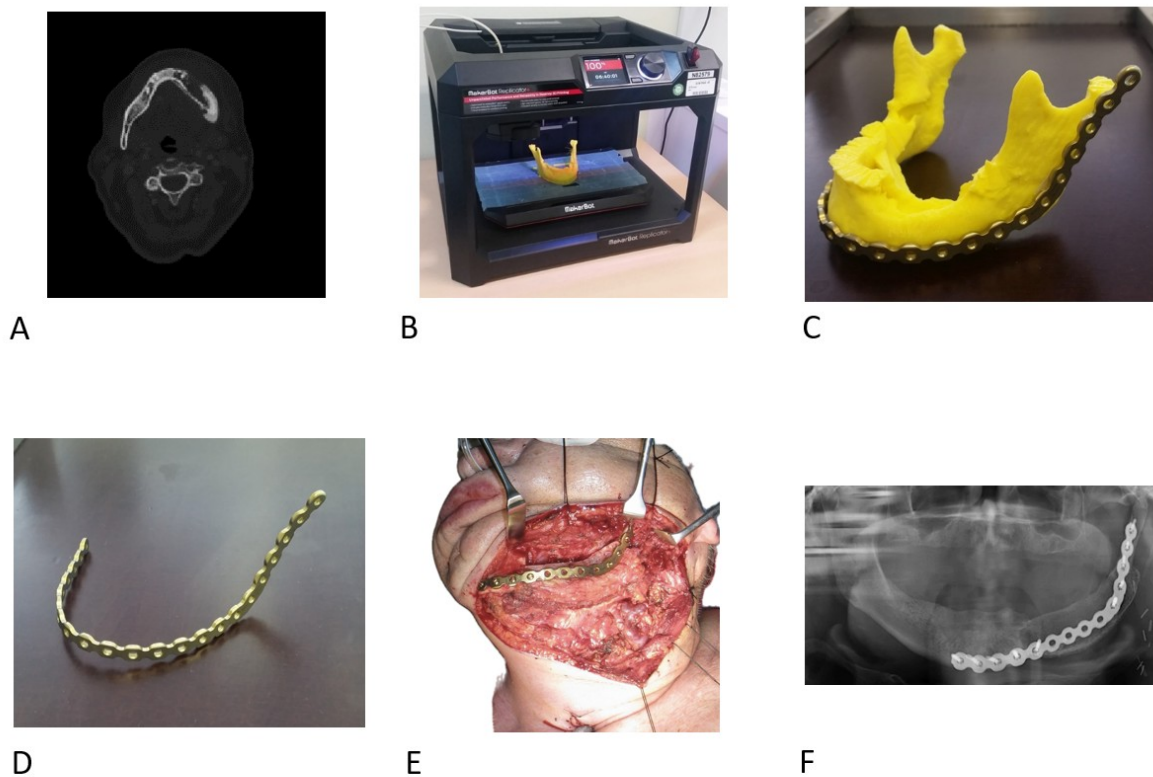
Preparatory work and clinical application as it is performed at the Division of Oral and Maxillofacial Surgery Graz, demonstrating mandibular reconstruction using the Modus 2.5 locking reconstruction plate. (A) The 3D data from the CT scan serves as the basis for the production of a model of the lower jaw, (B) which is manufactured using a 3D printer. (C) After studying the model precisely (D) the plate is adapted and after sterilisation (E) intraoperatively used. (F) The postoperative OPG showing the reconstruction with the used plate in situ.*
